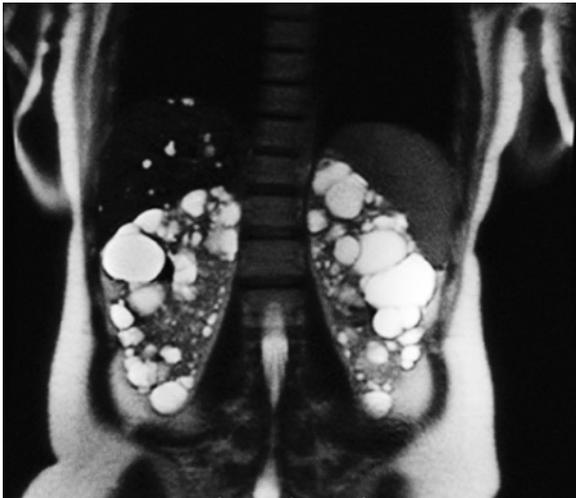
Magnetic resonance image of the abdomen in the patient with ADPKD. The massively enlarged kidneys, each with innumerable cysts of varying sizes, represent the typical ADPKD phenotype. Polycystic liver disease, also present in this patient, is highly prevalent in ADPKD
